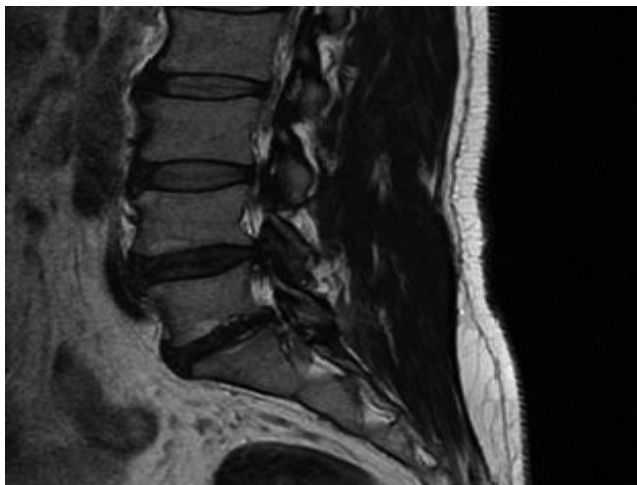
Magnetic resonance imaging of lumbar vertebra revealed increased signal and bone marrow edema at lower spine
